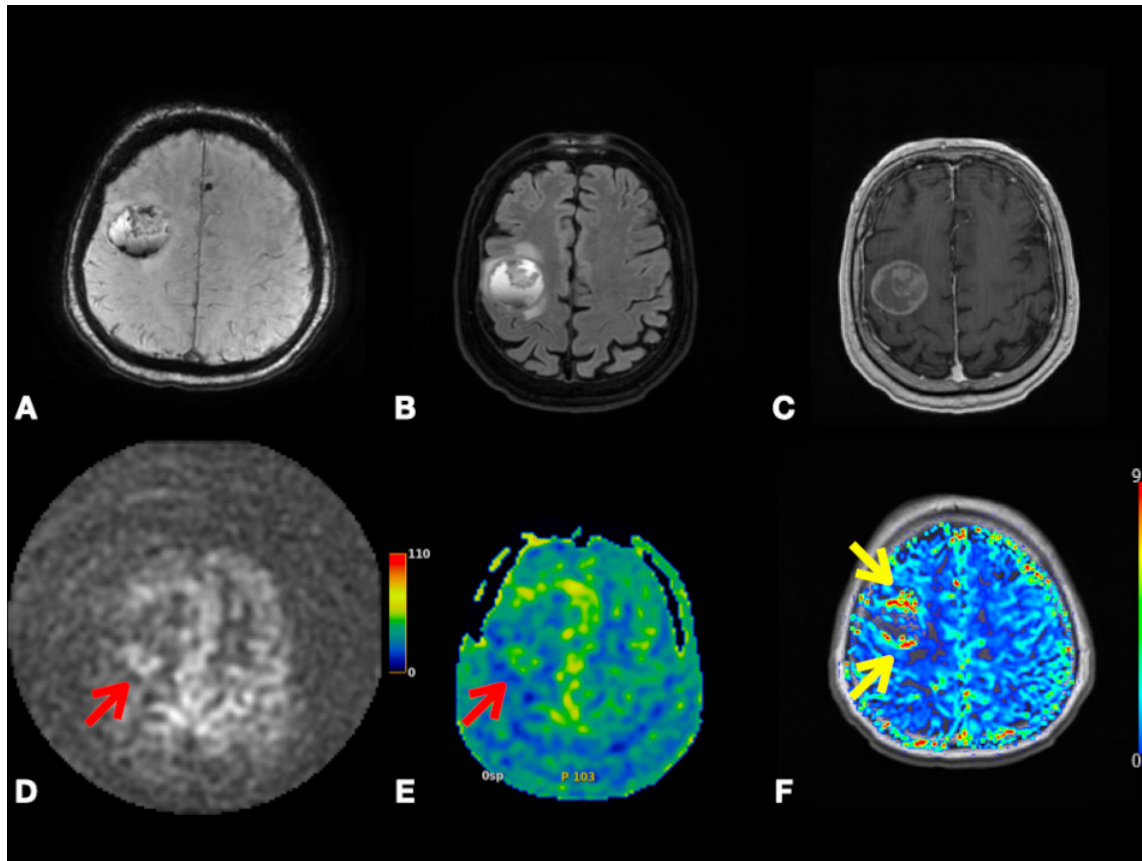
Right frontal lobe non-small cell lung cancer metastasis. Axial SWI (A), FLAIR (B), and post-contrast T1-weighted (C) images depicting lesion with heterogenous enhancement, perilesional vasogenic edema, central necrosis, and intralesional hemorrhage. Axial pcASL source data (D), color-coded CBF map (E) from pcASL data, and color-coded rCBV map (F) from DSC data depicting heterogenous hyperperfusion amongst nodules at super lesion margin (red arrowheads) and enhancing margins elsewhere (yellow arrowheads). Abbreviations: SWI, Susceptibility weighted imaging; FLAIR, Fluid attenuated inversion recovery; pcASL, Pseudo-Continuous Arterial Spin Labeling; CBF, cerebral blood flow; rCBV, relative cerebral blood volume; DSC, Dynamic susceptibility contrast MR imaging.
